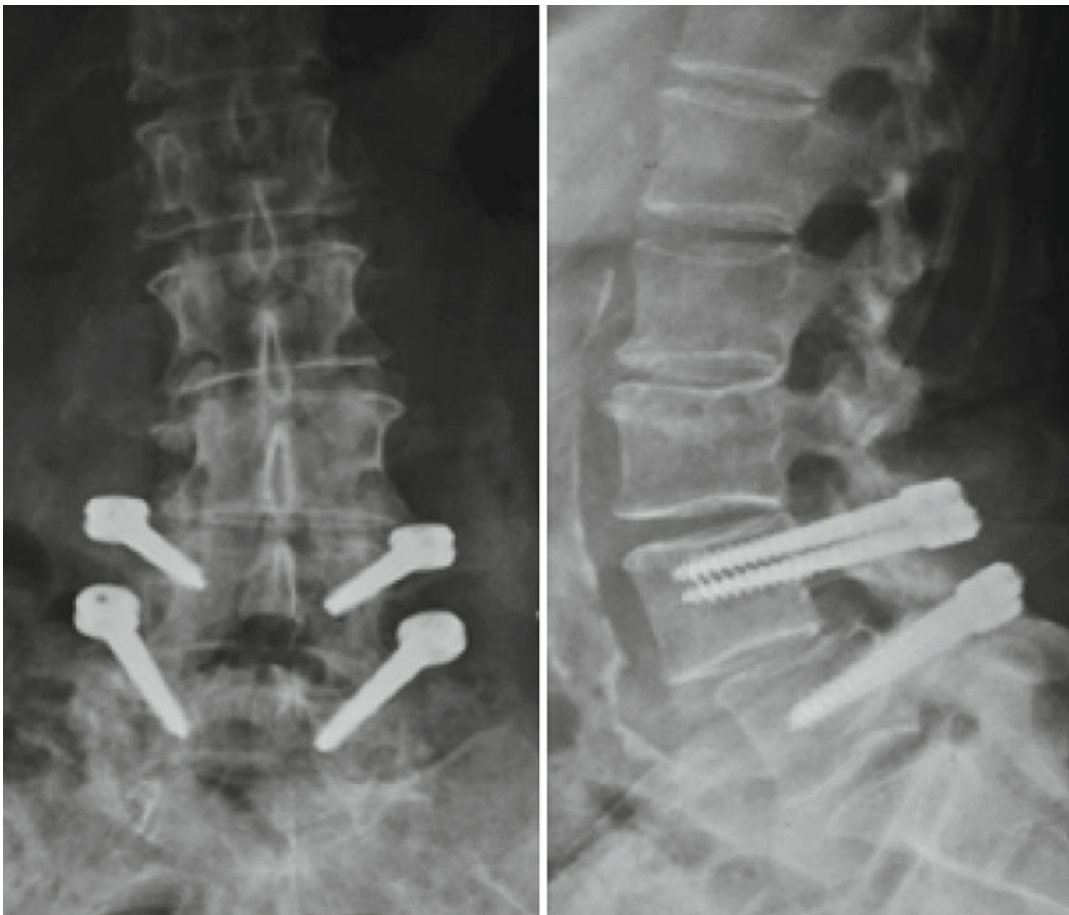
AP and lateral radiograph demonstrating the Dynesys system for lumbar posterior spinal fixation
